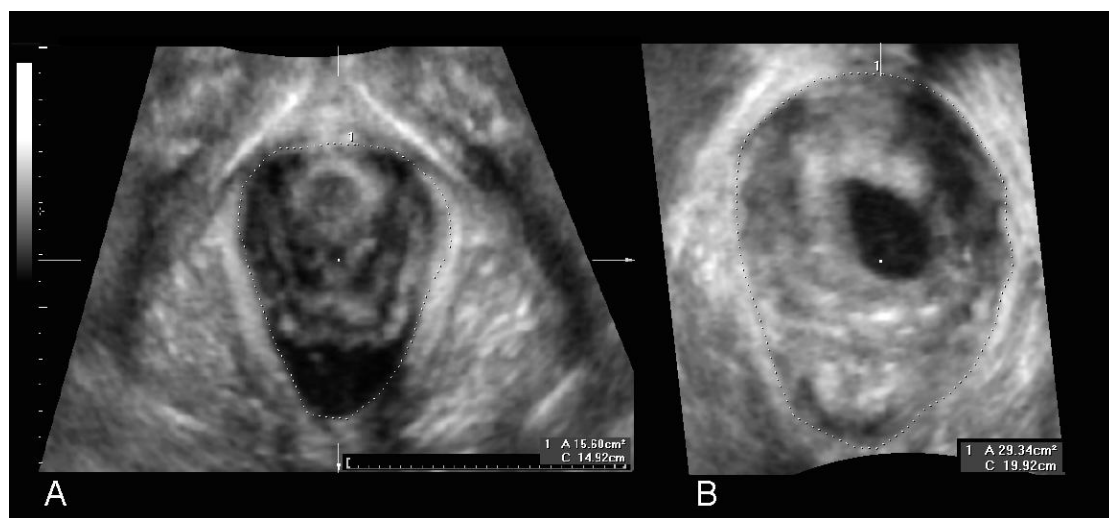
Antepartum and postpartum ultrasound images (single slice axial planes in the plane of minimal hiatal dimensions) of a patient with left sided avulsion after Forceps delivery. The hiatal area on maximum Valsalva at 38 weeks (on the left, image A) was 15.6 cm². It was measured at 29.3 cm² at 4 months postpartum (image B).
